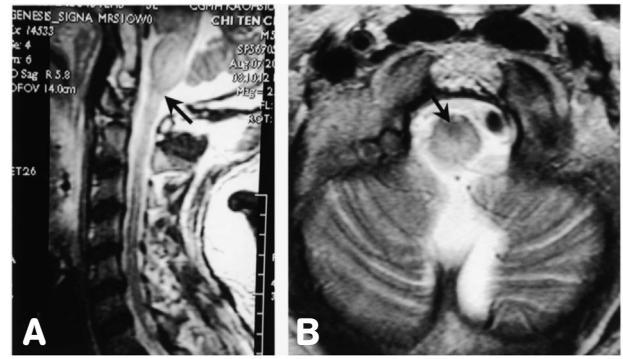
(A) Saggittal T2-weighted (4500/120[TR/TE]) MR image showed an extensive high signal lesion in the upper cervical cord, medulla oblongata and lower pons (arrow). (B) Axial T2-weighted (4000/120 [TR/TE]) MR image showed a high signal lesion in the medulla oblongata, whose ventral part was relatively spared (arrow).
